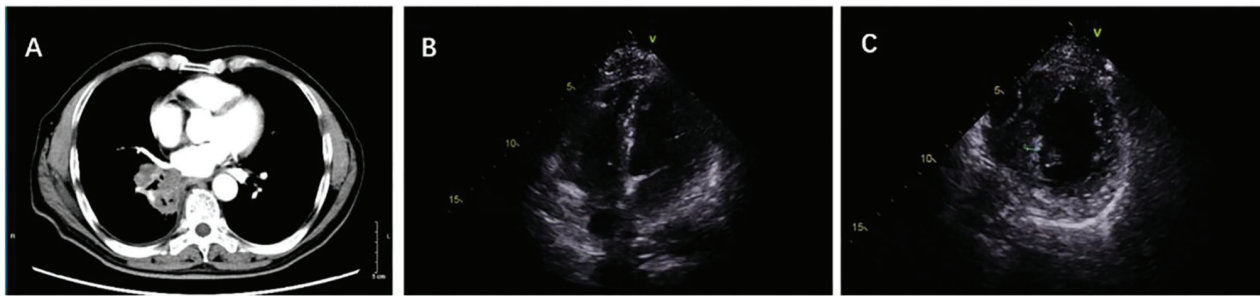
Primary tumor and metastases after two cycles of immunotherapy. (A) Chest computed tomography shows that the irregularly shaped parahilar mass in the lower lobe of the right lung invading the pulmonary veins and left atrium was markedly reduced in size to  $\sim 4.5 \times 3.3$  cm. (B) Transthoracic echocardiography showed no abnormal echo in the left atrium and (C) echogenic mass measuring  $\sim 0.8 \times 0.5$  cm attached to the middle of the posterior septum in the left ventricle.
